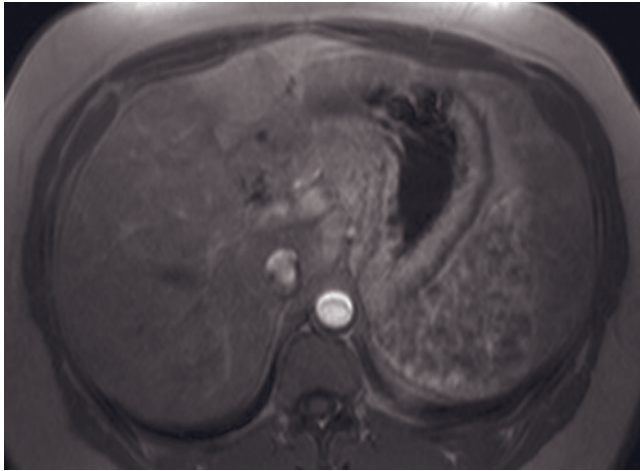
Hepatosplenic sarcoidosis. T2-weighted fat-suppressed SE (*a*), T1-weighted fat-suppressed SE (*b*), and immediate (*c*) and 5-min (*d*) postgadolinium SGE images. The spleen is massively enlarged and contains multiple <1-cm nodules that are moderately low signal intensity on T2-weighted (*a*) and T1-weighted (*b*) images and demonstrate negligible enhancement on early-phase images (*c*) with gradual enhancement over time (*d*). Extensive retroperitoneal, celiac, and periportal lymphadenopathy is also present (*a*, *b*), which has a speckled appearance on the T2-weighted image (arrows, *a*). A speckled signal on T2 has been described for lymph nodes affected by sarcoidosis.
